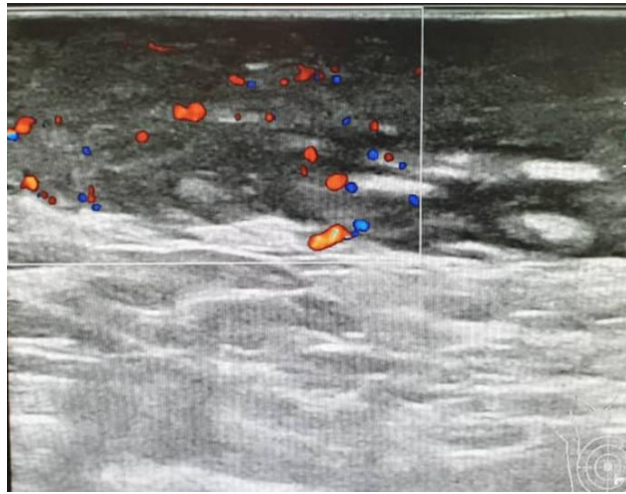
Shows ultrasound peri areolar region with increase color doppler
